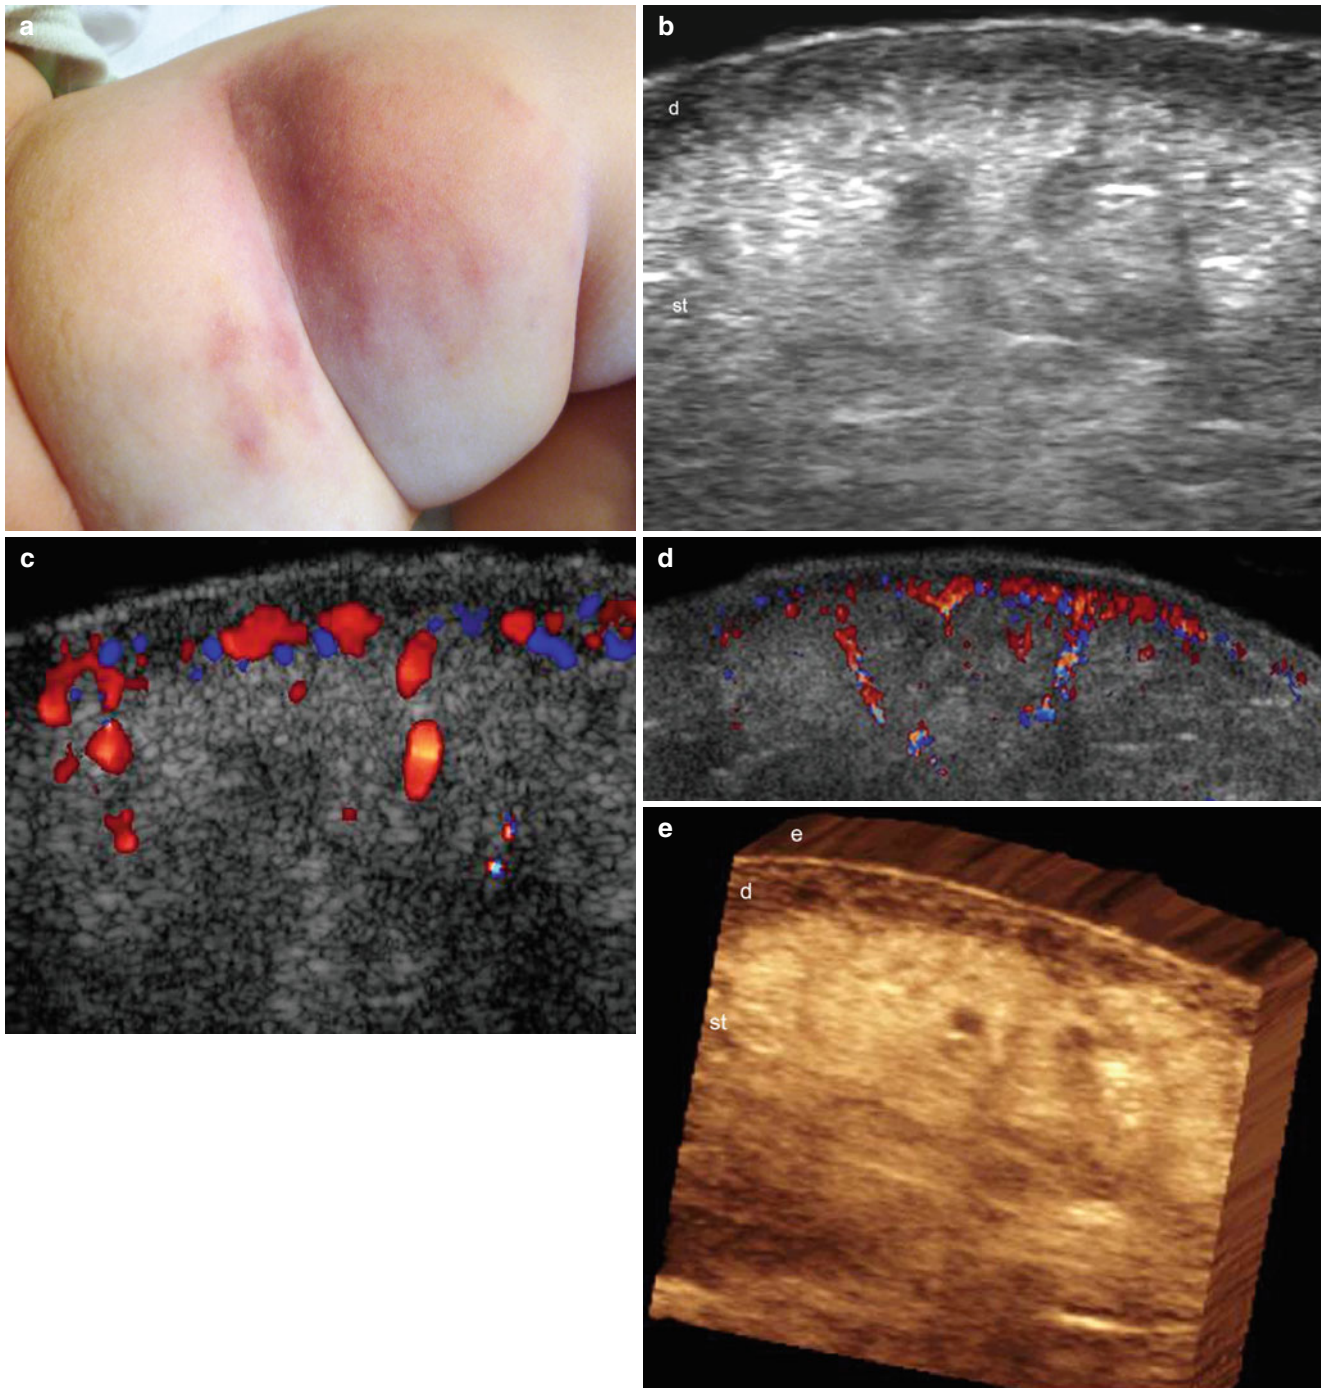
(a–e) Active morphea (inflammatory phase). (a) Clinical erythematous swelling in the left thigh of an infant. (b) Gray scale ultrasound image (transverse view) shows thickening and decreased echogenicity of the dermis and increased echogenicity of the subcutaneous tissue. (c) Color Doppler ultrasound image (transverse view)
